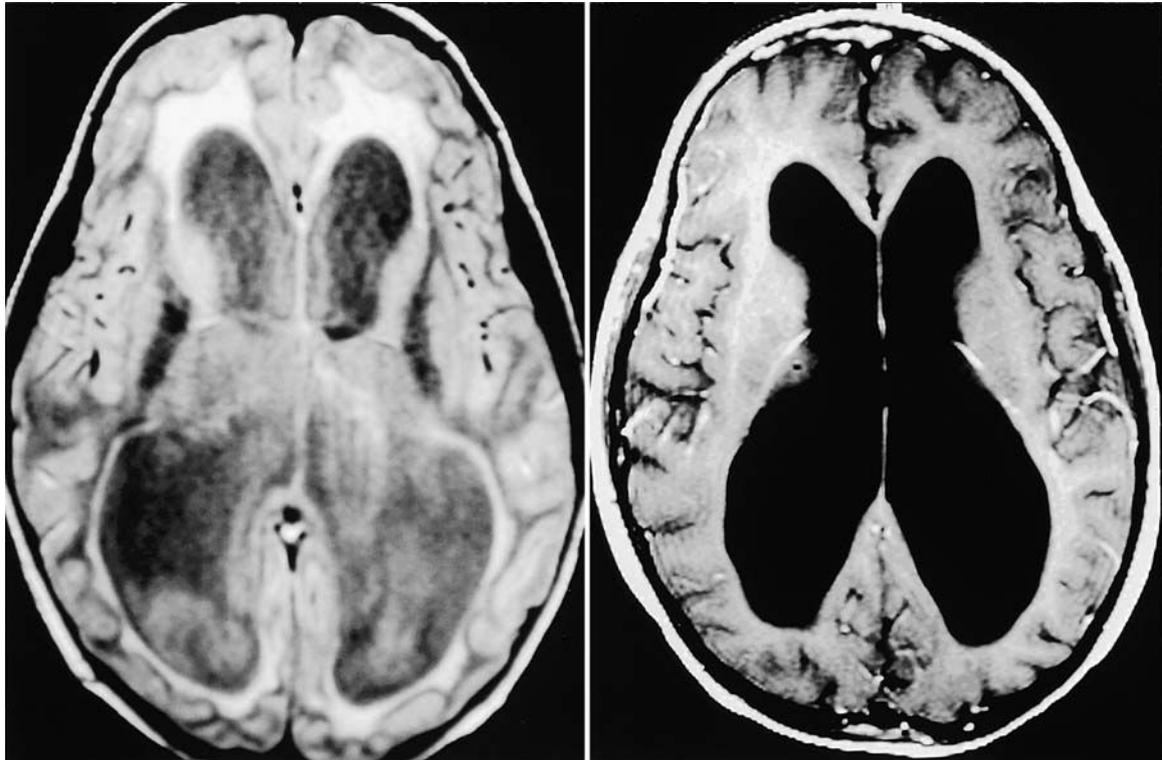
Case 1. *Left*: Axial fluid-attenuated inversion-recovery MR image demonstrating enlargement of lateral ventricles with surrounding periventricular edema. *Right*: Axial T₁-weighted MR image obtained after third ventriculostomy demonstrating resolution of periventricular edema and an increase in convexity CSF.
